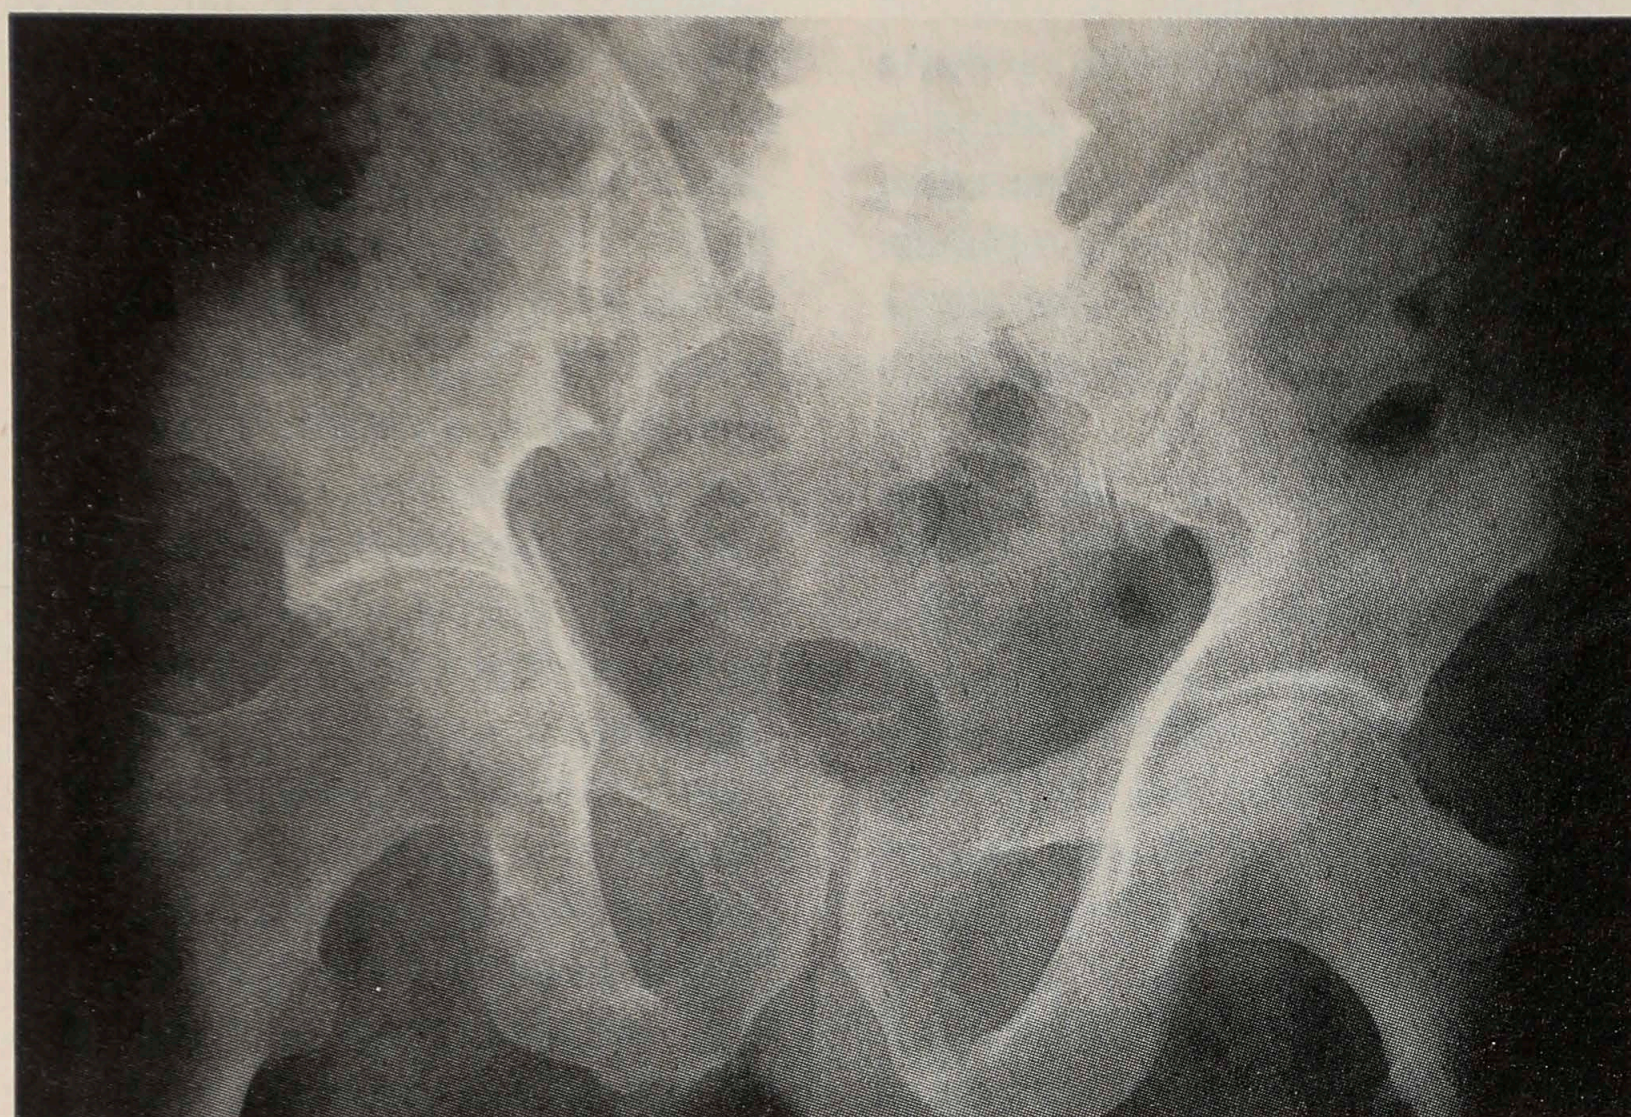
Radiograph shows pathologic fracture of right acetabulum after therapy for bone lymphoma.
